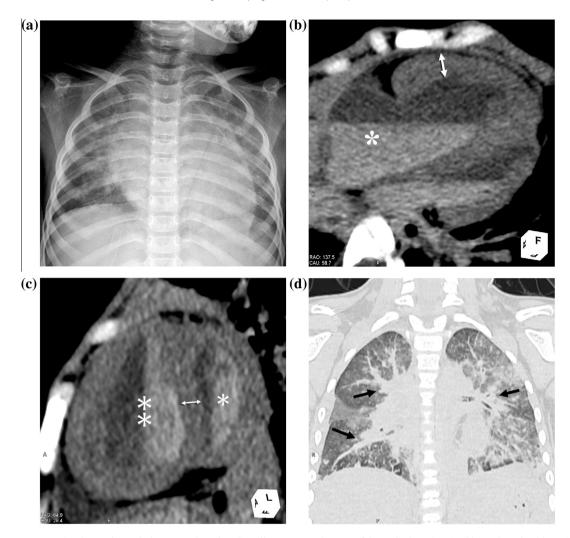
(a) Supine anteroposterior chest radiograph shows an enlarged cardiac silhouette exceeding 50% of the cardiothoracic ratio. (b) In order to be able to visualize the small density differences within cardiac wall and cavity, quite narrow image window arranged (window width = 90 Hounsfield unit (HU), window level = 50 HU). Horizontal long-axis heart multiplanar reconstruction (MPR) computed tomography (CT) image (i.e., four-chamber view) shows thickening of the right ventricular wall (double-headed arrow), a dilated tricuspid annulus (arrow), and an enlarged right atrium (star). The blood in the heart is separated into two layers due to postmortem hypostasis. (c) Short-axis heart MPR CT image shows an enlarged right ventricle (double asterisk) and thickening of the interventricular septum (double-headed arrow). The left ventricle is normal in size (asterisk). (d) Coronal lung MPR CT image shows consolidation around the bilateral hilar area and a thickened bronchovascular bundle (arrows). A ground-glass opacity is seen in the peripheral region of the lungs.
